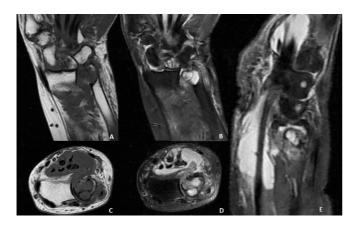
There is a view that is heterogenously hyperintense on t2 weighted image and that is isointense with muscle on t1 weighted image around distal ulna on MRI. There has been minimal effusion on distal radioulnar and proximal carpal joints. Effusion related to tenosynovitis around carpal tunnel and extensor carpi ulnaris tendon. A degenerative cystic lesion was observed in lunate bone.
